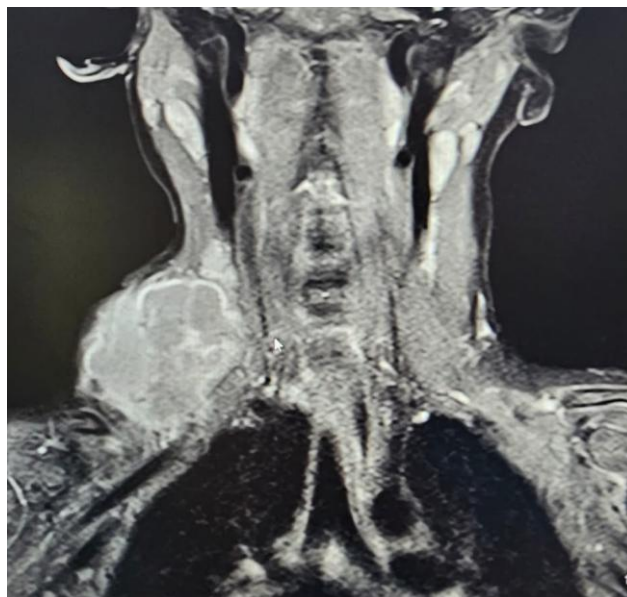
MRI with contrast showing giant cystic lymphangioma of right lower neck with early compression of surrounding structures
